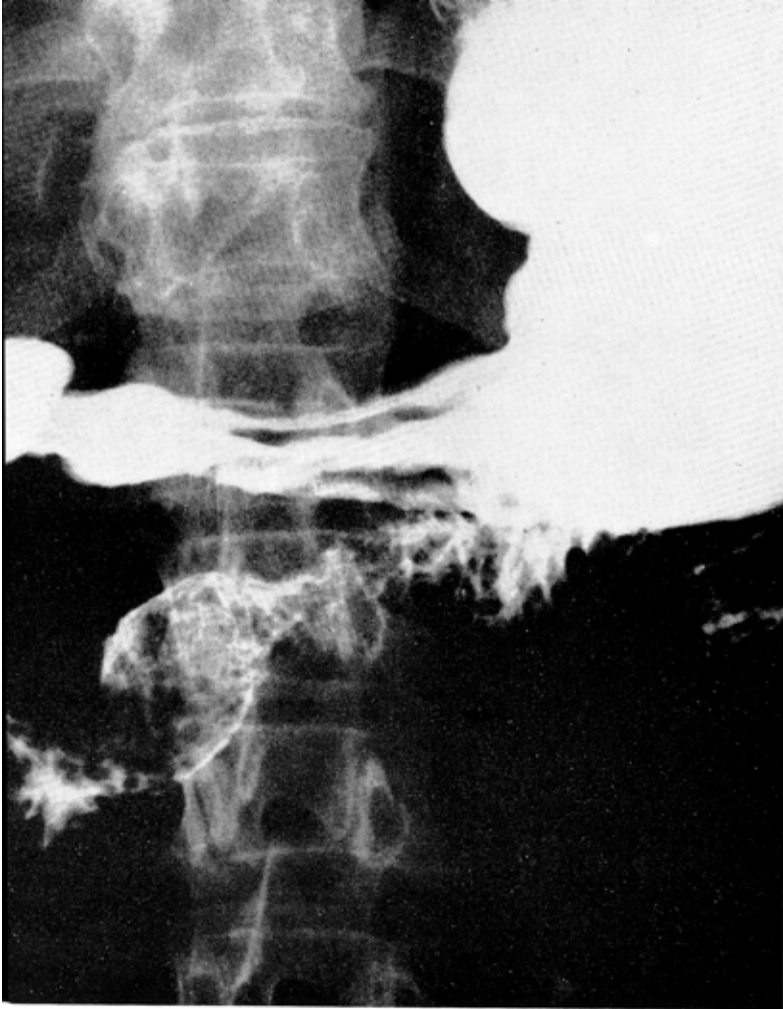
Roentgenogram showing filling defect at the junction of the second and third duodenal portions.
